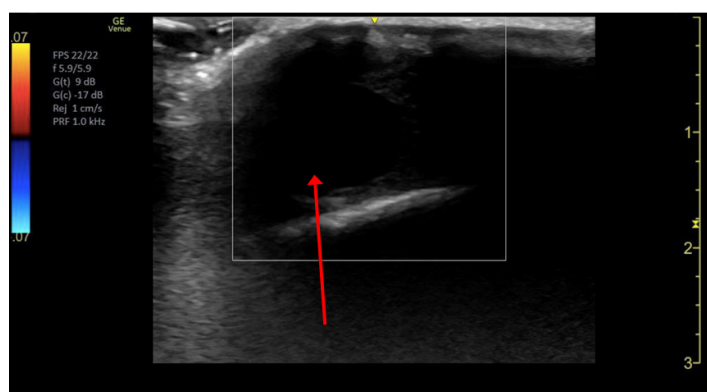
B-mode ultrasound demonstrating a hypoechoic fluid collection within the scalp measuring $2.9 \times 1.5 \times 2.9$ centimeter.
